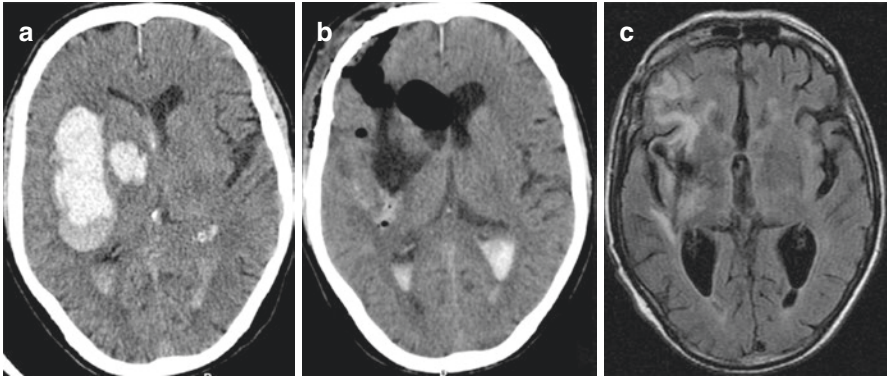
Right putaminal ICH with intraventricular extension (a), in a 61-year-old male, on acenocoumarin for atrial fibrillation (INR 2.78). The senior surgeon opted for CT-guided endoscopic treatment, with a supraorbital key-hole approach to minimize procedure-associated morbidity and preserve cerebral cortex directly superficial to the hematoma. (b) Demonstrates a good drainage of the hematoma, and the patient evolved favorably, with mRankin of two 14 months after the event (c), with minor cognitive dysfunction and grade IV+ left hemiparesis. (Case from author's departmental archive)
